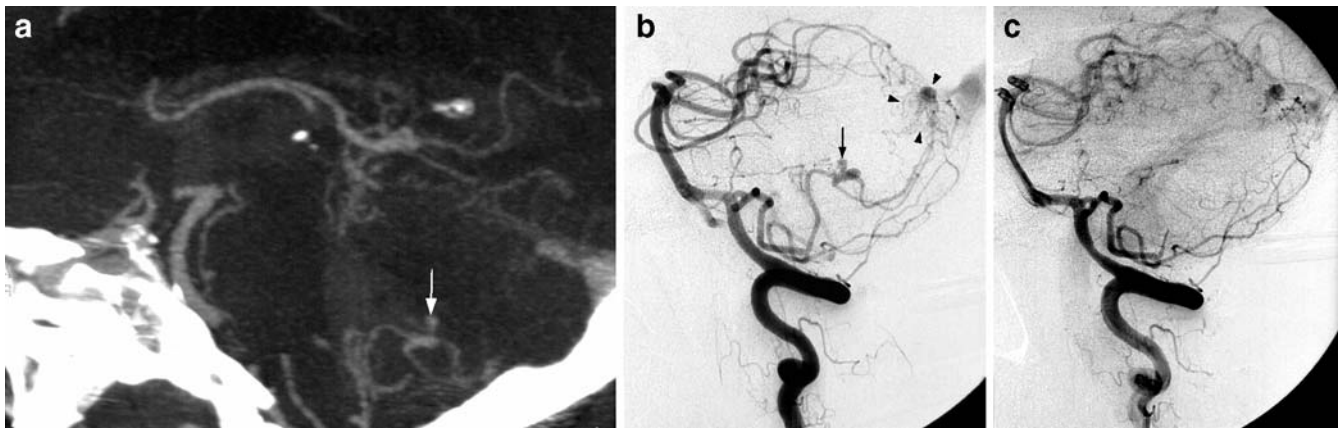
a Sagittal CTA reconstruction showing an isolated distal left PICA aneurysm (*arrow*). b Lateral projection, left vertebral angiogram, demonstrates a small peripheral AVM (*arrowheads*)
